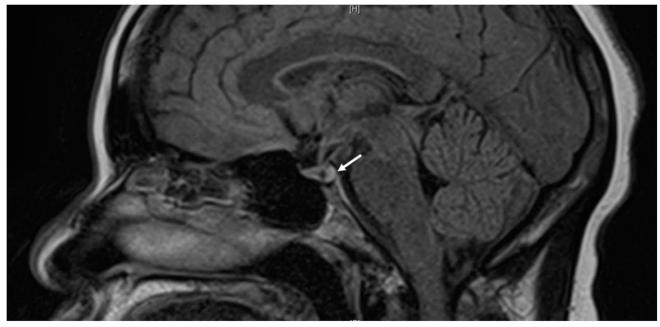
Sagittal view of brain MRI showing the bright signal (arrow) indicating intact AVP neurohypophysis.
